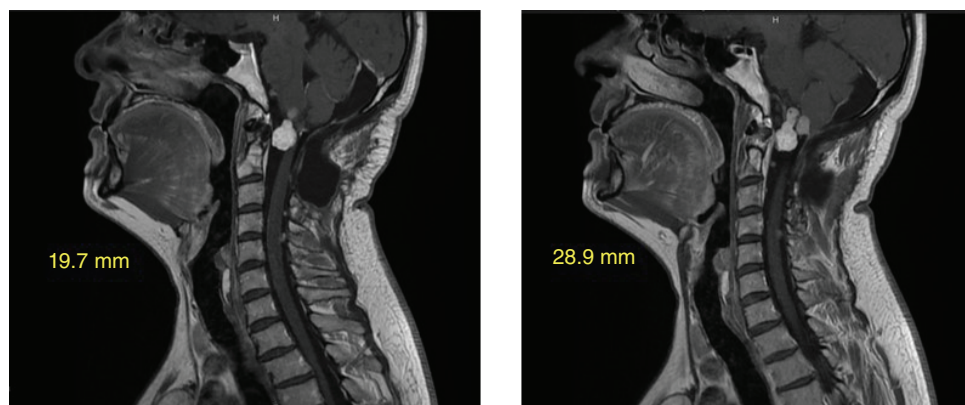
November 2018: adjacent slices from T1 MRI sequences showing progressive cervical disease.
